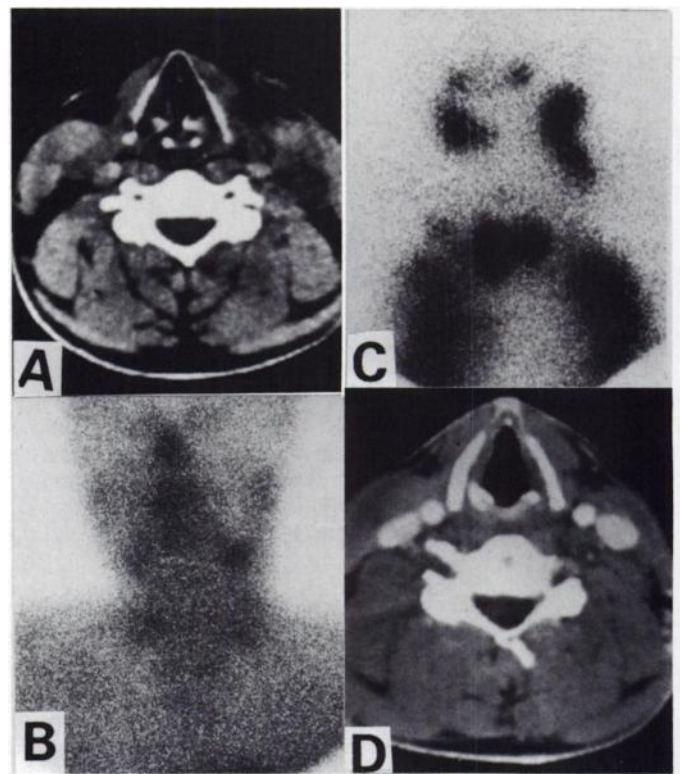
A 21-yr-old man with cervical lymph node metastasis from papillary carcinoma. (A) Pretreatment CT scan shows lymphadenopathy in the left neck. (B) Thallium-201 uptake in the tumor is low (T/B 1.24). (C) Iodine-131 uptake in the tumor is good. Unexpected uptake is also noted in the right neck and the lung field. (D) Post-treatment CT scan shows complete disappearance of the lymph node. The therapeutic outcome is effective.
